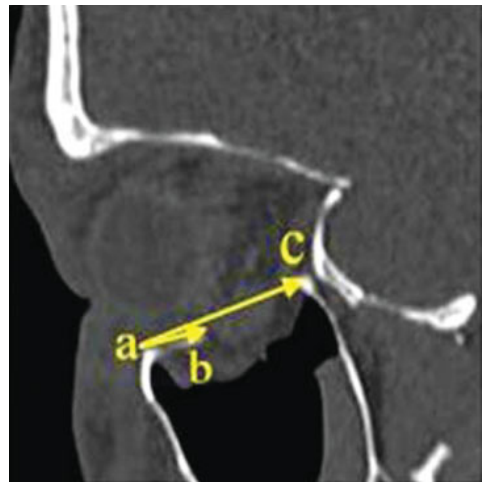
Sagittal computed tomography slice where the fracture is considered largest. (A) Infraorbital margin, (B) anterior, and (C) the posterior part of the fracture.
